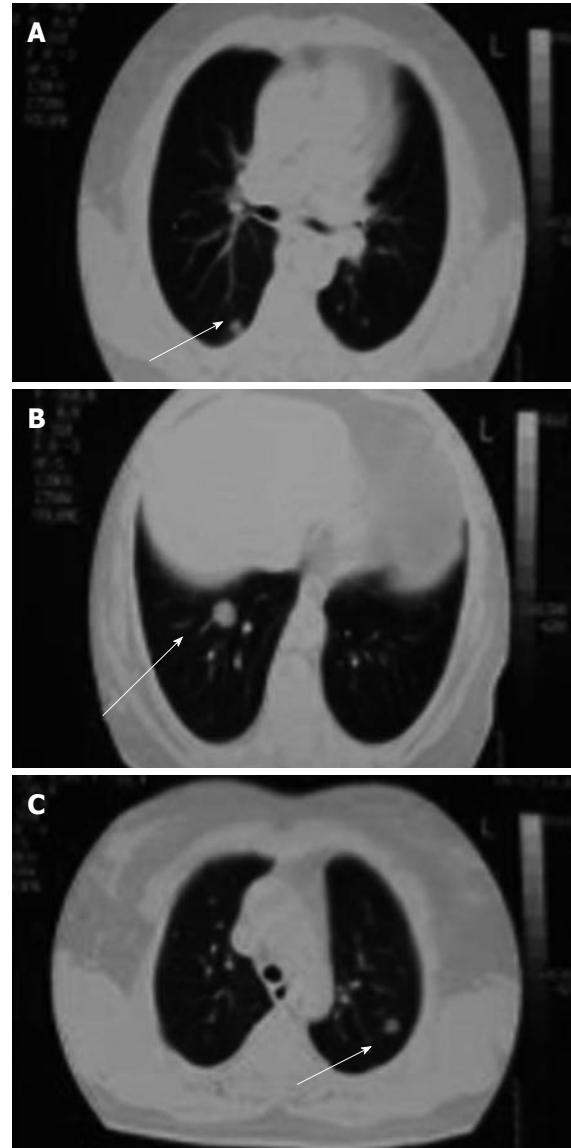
Bilateral pulmonary metastases in the chest computed tomography image.
